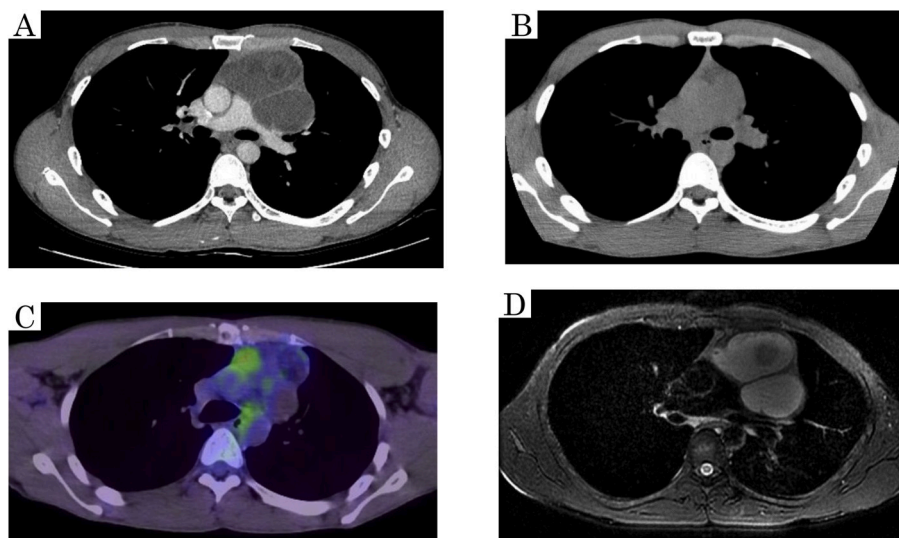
Radiological examinations. A: Contrast-enhanced CT showing a large heterogenous mass shadow containing multiple cysts in the anterior mediastinum. B: There were no abnormal findings on the chest CT taken last year. C: PET-CT showing a low uptake only in the upper area of the mass. D: T2-weighted MRI showing high intensity areas predominantly consistent with multiple cysts.
